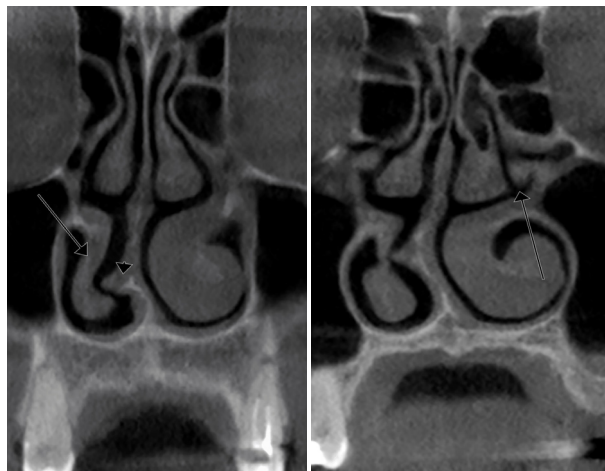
Cone beam CT coronal MPR of the nasal fossae. On the right side, we identified a paradoxical inferior turbinate (arrow) and a corresponding horizontal septal crest (arrowhead).
